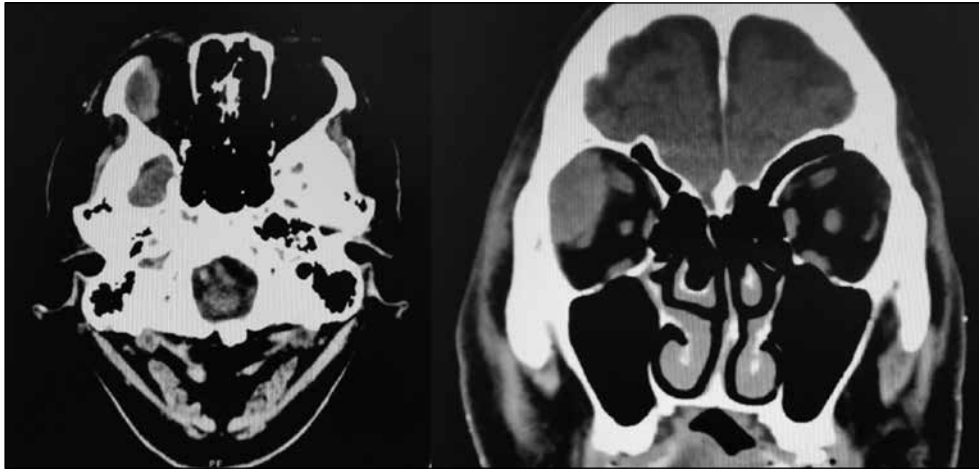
Computed tomography of the orbit showing a 2.4 cm rim-enhancing mass located at the extraconal region of the right orbit in the post-septa region displacing the lateral rectus muscle inferiorly. The mass is abutting on the superior and lateral orbital wall, lacrimal gland, and right globe, causing proptosis. The right lacrimal gland cannot be delineated from this lesion. There is no bony erosion, thickening, or lysis.
